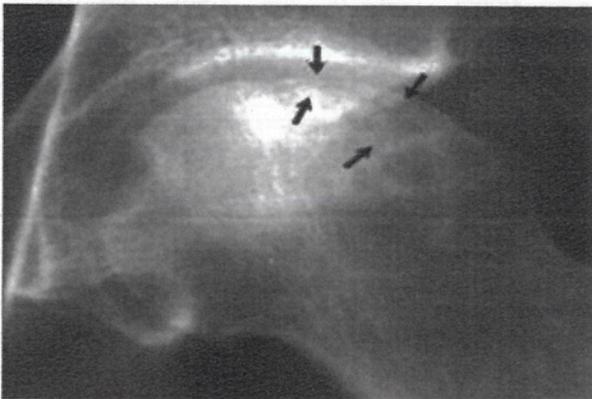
Anteroposterior pelvic radiography showing flattening of the superior aspect of the femoral head of the left side (Source: Radiopaedia)
